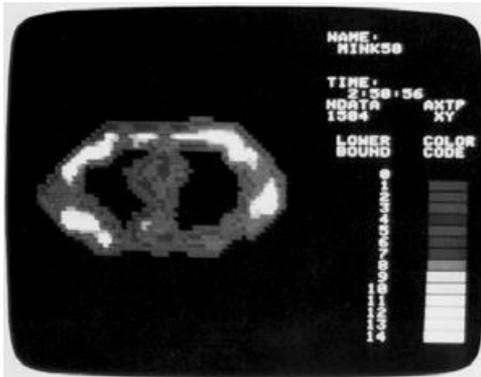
First human MRI scan in 1977 at 0.05 T of the abdomen, took 5 hours (Damadian et al. 1977)
